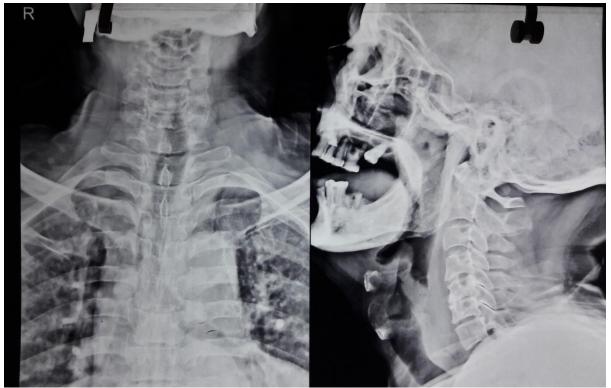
(a) X-Ray neck (including chest), AP andLateral view Fig 1.
